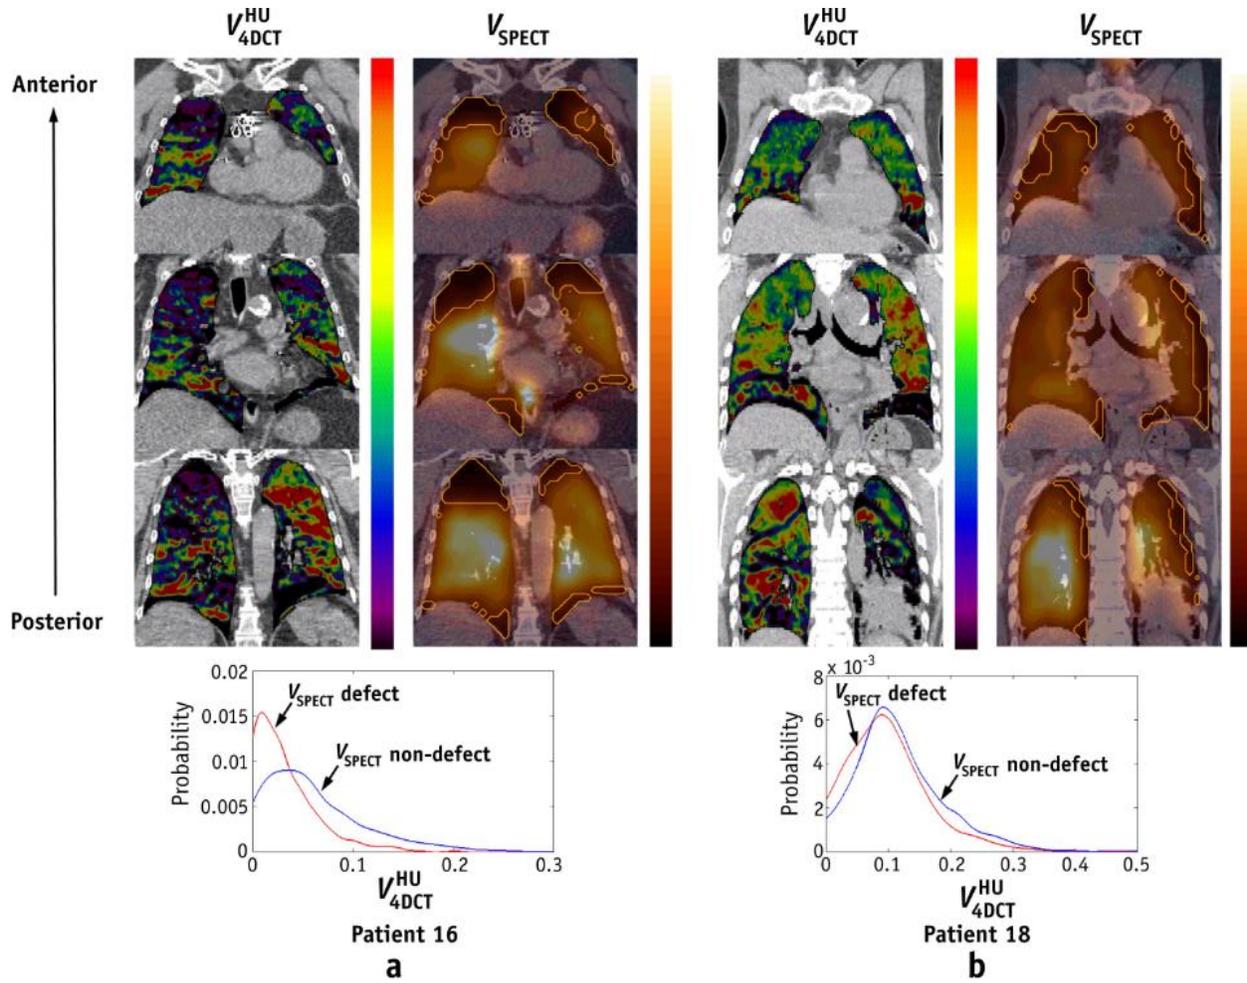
Comparison of V_{4DCT}^{HU} and V_{SPECT} for (a) patient 16, showing a large separation between the probability density functions of V_{4DCT}^{HU} in V_{SPECT} defect regions and nondefect regions, and (b) patient 18, showing a small separation. Orange outlines in V_{SPECT} denote defect regions. Both V_{4DCT}^{HU} and V_{SPECT} are shown with a scale from zero to the 90th percentile value.
